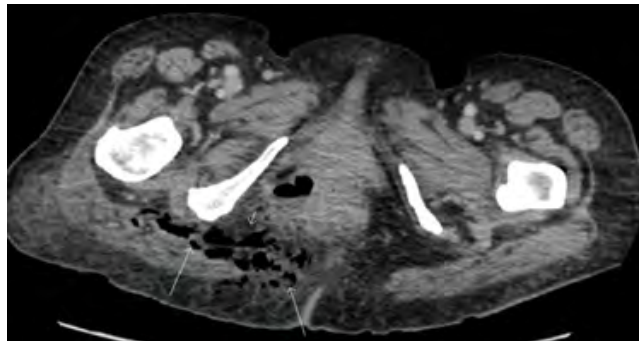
CT Abdominal/pelvis portal venous axial image to demonstrated multiple gas locules in the right perianal region extending to the right buttock soft tissues.
